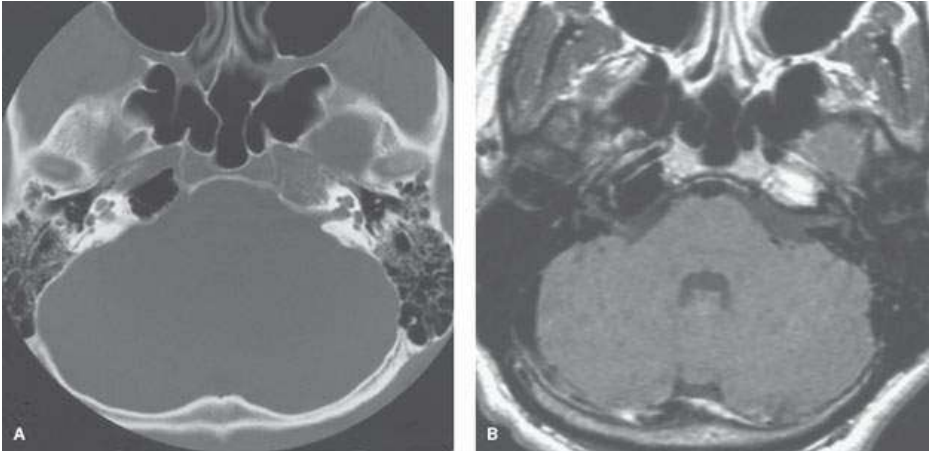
Normal variations of the petrous apex. Asymmetric appearance of the petrous apex due to variations in pneumatization. Computed tomography (A) and magnetic resonance (B) images show fatty marrow in the left petrous apex, whereas the right is well pneumatized.
